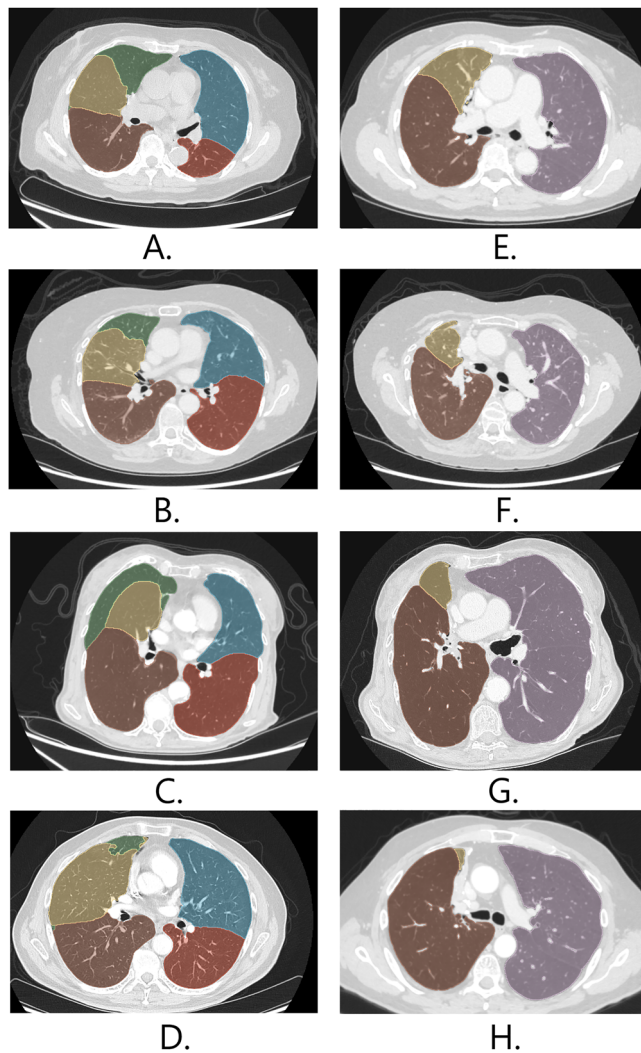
Axial CT slices showing preoperative (left column) and 6-month postoperative (right column) lobe segmentations in patients with increasing grades of atelectasis. The lobe in yellow in right column depicts the progressively increasing grades of atelectasis: minimal (grade 1) (A, E), subsegmental (grade 2) (B, F), segmental (grade 3) (C, G), and lobar atelectasis (grade 4) (D, H). Lobe labels (colors): RUL (green), RML (yellow), RLL (brown), LUL (blue), LLL (red), LL (pink) (RUL right upper lobe, RLL right lower lobe, RML right middle lobe, LUL left upper lobe, LLL left lower lobe).
